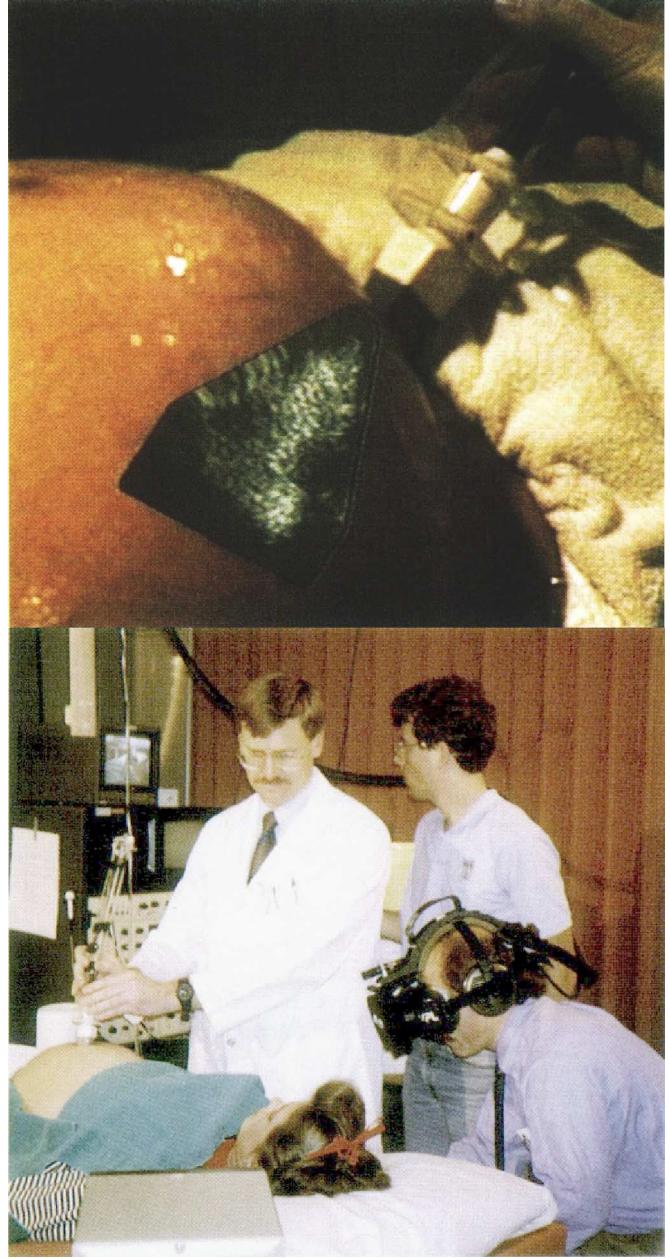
First video see-through HMD: Augmentation of ultrasound slices [12].
